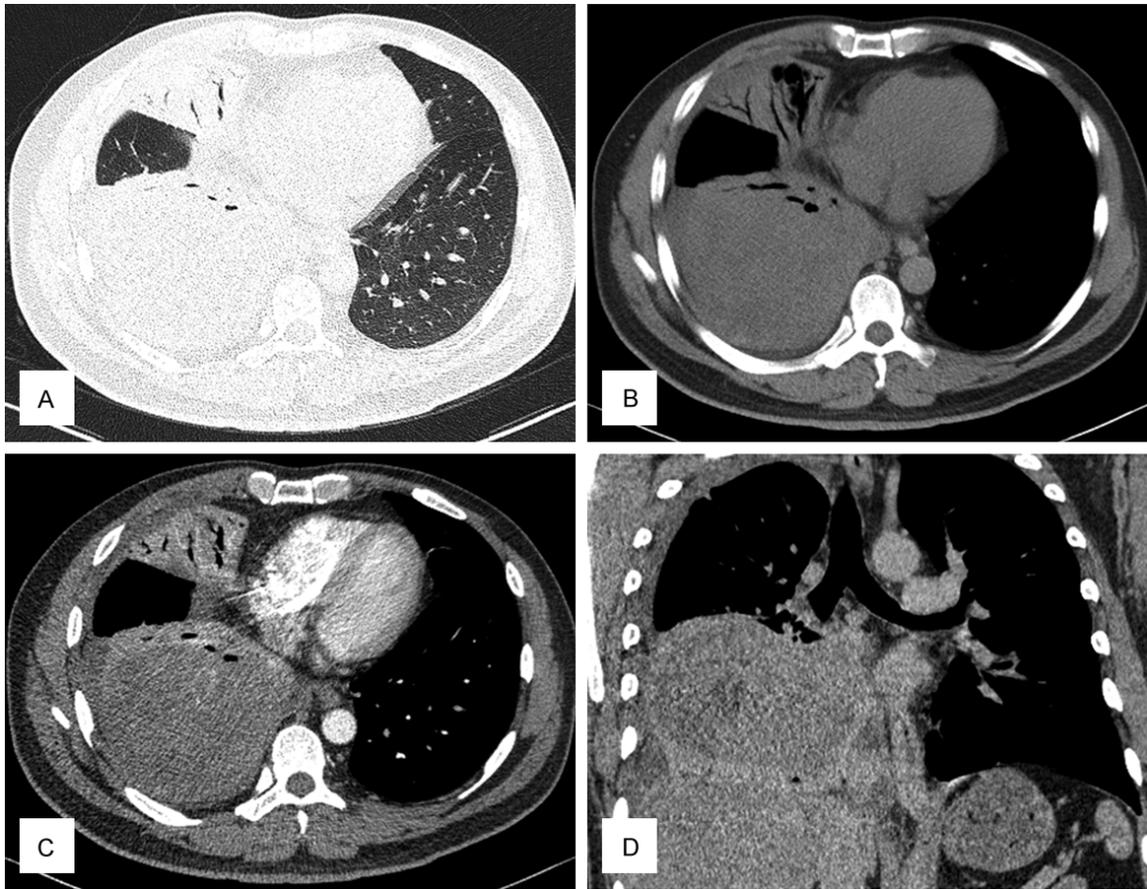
Chest computed tomography scan. (A) Under a noncontrasting enhanced CT scan, a well-defined 10.2 cm × 11.8 cm mass with non-uniform density was observed in the lower-right lung lobe. (B) It was connected to the pleura by a wide base and displaced adjacent lung tissues. Liquid density was seen on the right side of the thoracic cavity. (C, D) Under an enhanced CT scan, the mass presented heterogeneous enhancement with patchy low density in the arterial (C) and delayed phase (D).
